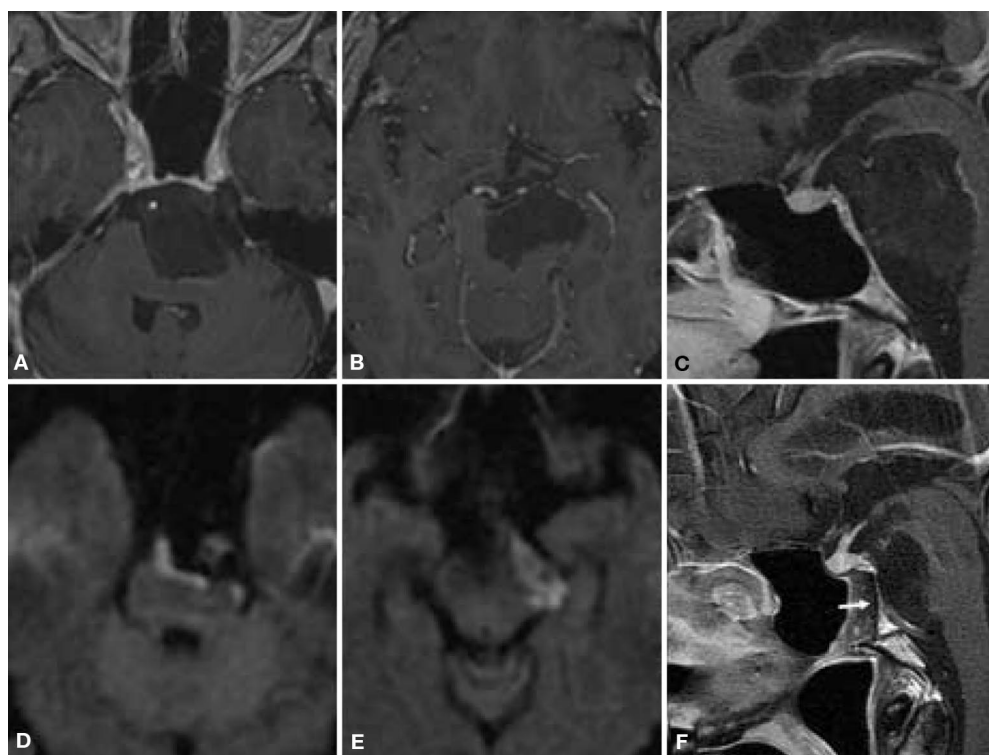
Sellar MRI scans of Patient 1. Preoperative axial (A and B) and sagittal (C) images after intravenous gadolinium diethylenetriamine penta-acetic acid: a large ventral brainstem mass occupies the posterior suprasellar, interpeduncular, premesencephalic, prepontine, and perimedullary cisterns with extension to the left. The basilar artery is encased, and the other proximal major intracranial vessels are displaced. One-year postoperative axial DWI image (D and E) and sagittal postgadolinium image (F) show a thin rim of residual tumor against the brainstem, especially in the left interpeduncular, perimesencephalic, and prepontine cisterns. However, the degree of mass effect on the brainstem is greatly reduced. The titanium mesh buttress is seen covering the clival bony defect (arrow).
